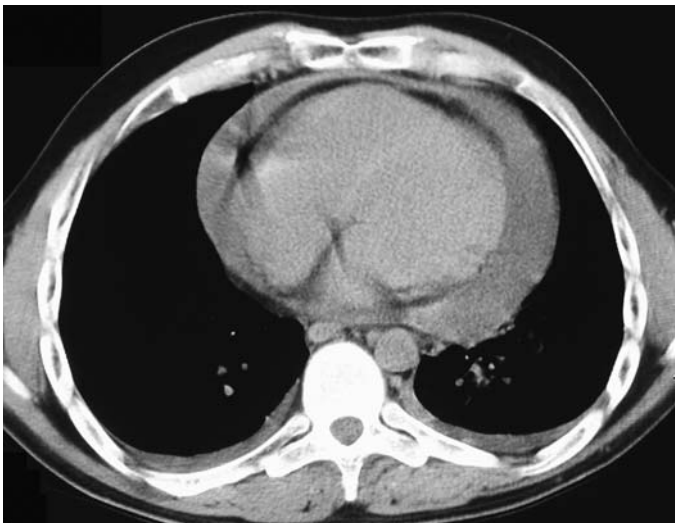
FIGURE e28-7 Computed tomography of the chest demonstrating a large pericardial effusion in a patient with Churg-Strauss syndrome. Cardiac involvement is an important cause of morbidity and mortality in Churg-Strauss syndrome and can include myocarditis, endocarditis, and pericarditis.
